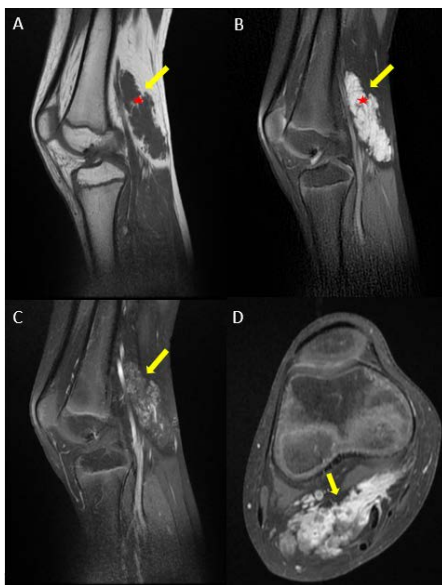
MRI of the right knee of an 8 years old girl, with sagittal view in T1 weighted sequence (A), T2 FS weighted sequence (B), T1 sagittal and axial enhanced sequences in portal phase (C) (D), showing a well-defined, extra-articular mass of the knee developed in the gastrocnemius muscle, isointense in the T1 sequence, hyperintense in T2 FS, with delayed enhancement after Gadolinium injection and fatty linear spots (red star), leading to diagnosis of intra muscular venous angioma.
